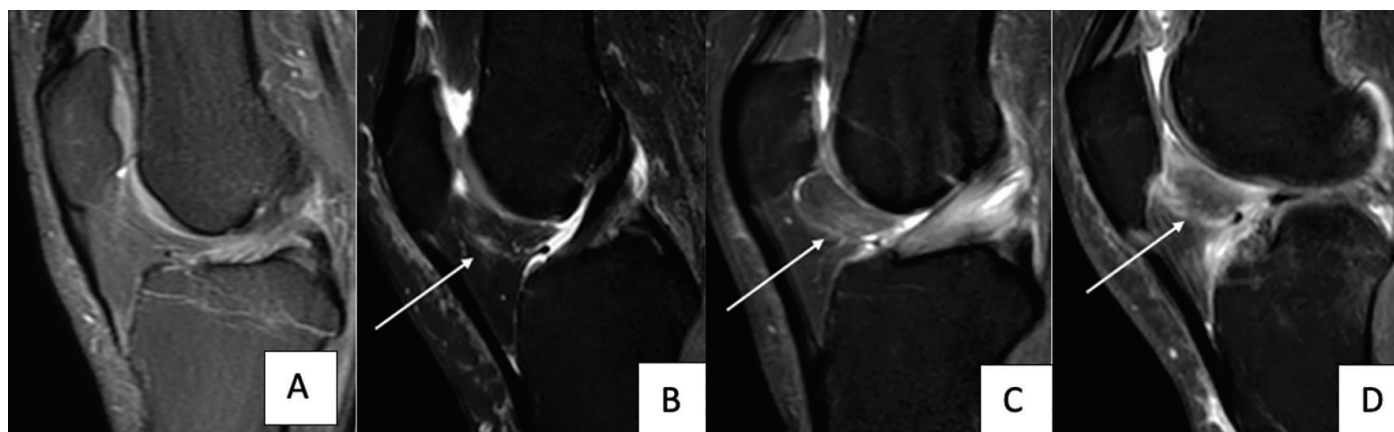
Classification of infrapatellar fat pad (IPFP) signal intensity alterations on MRI. The white arrows indicate regions of increased signal intensity within the IPFP. Each grade represents the percentage of IPFP involvement: Grade 0, no alteration; Grade 1, $\leq 10\%$; Grade 2, $10\text{--}20\%$; Grade 3, $\geq 20\%$
